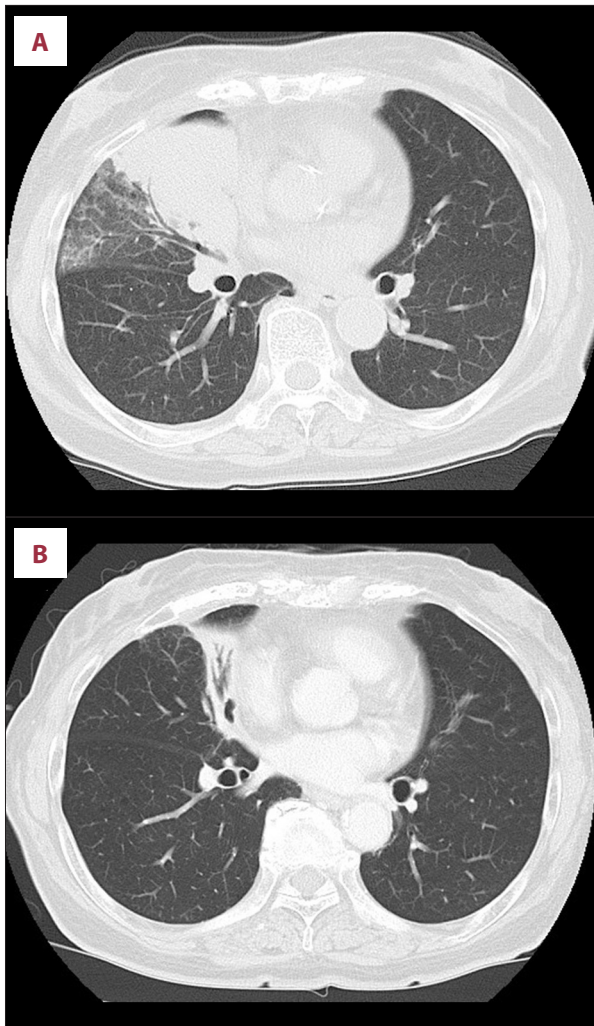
(A) Chest CT at diagnosis (April/202X): A large tumor is observed in contact with the pericardium, although CT alone cannot determine whether myocardial invasion is present. (B) Chest CT after concurrent chemoradiotherapy (CCRT) (September/202X): The tumor has shrunk, and only a small shadow remains after CCRT was performed; this indicates a therapeutic effect of CCRT. (C) Chest CT at the onset of myocarditis as an irAE (May/202X+1): circumferential pericardial effusion and predominantly right-sided pleural effusion are observed.
